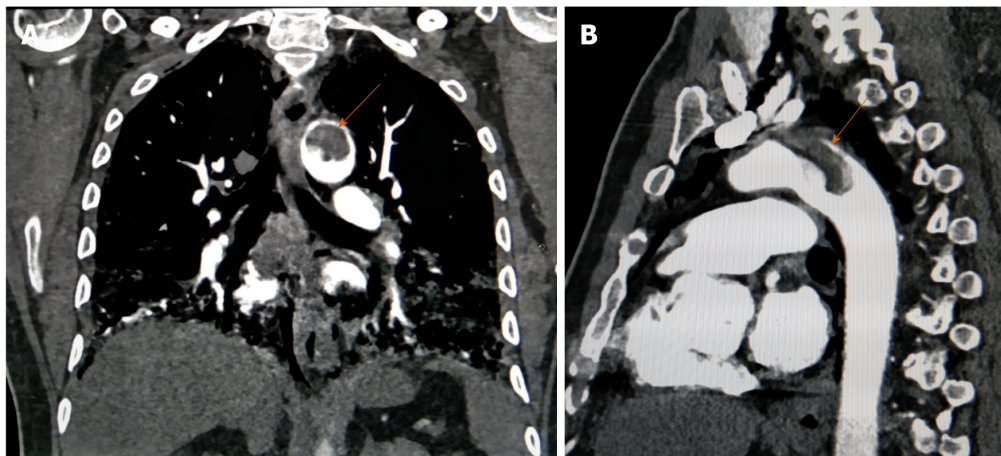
A 64-year-old male with aortic mural thrombosis. A and B: Coronal and sagittal sections of arterial phase of contrast-enhanced computed tomography thorax show pedunculated thrombus in aortic arch suggestive of aortic mural thrombus.
